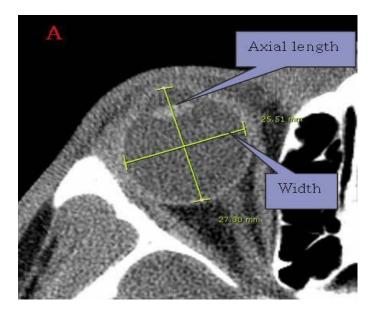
CT image of axial length.
